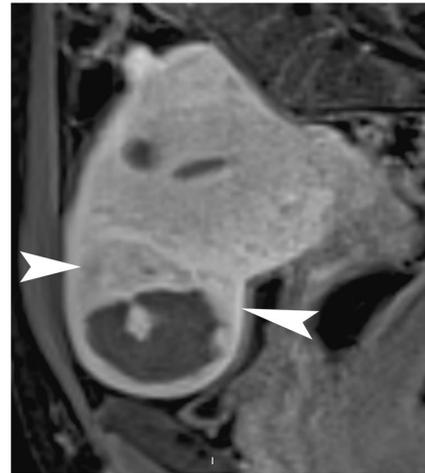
38-year-old woman who had uterine artery embolization (UAE) for symptomatic uterine leiomyomas. Gadolinium chelate-enhanced 3D-VIBE® sequence in the sagittal plane shows incomplete (0–89 % devascularization of the dominant leiomyoma on the 48-h post-UAE MR imaging. There is a persisting enhancement of more than 10 % of the leiomyoma volume (*arrowheads*)
